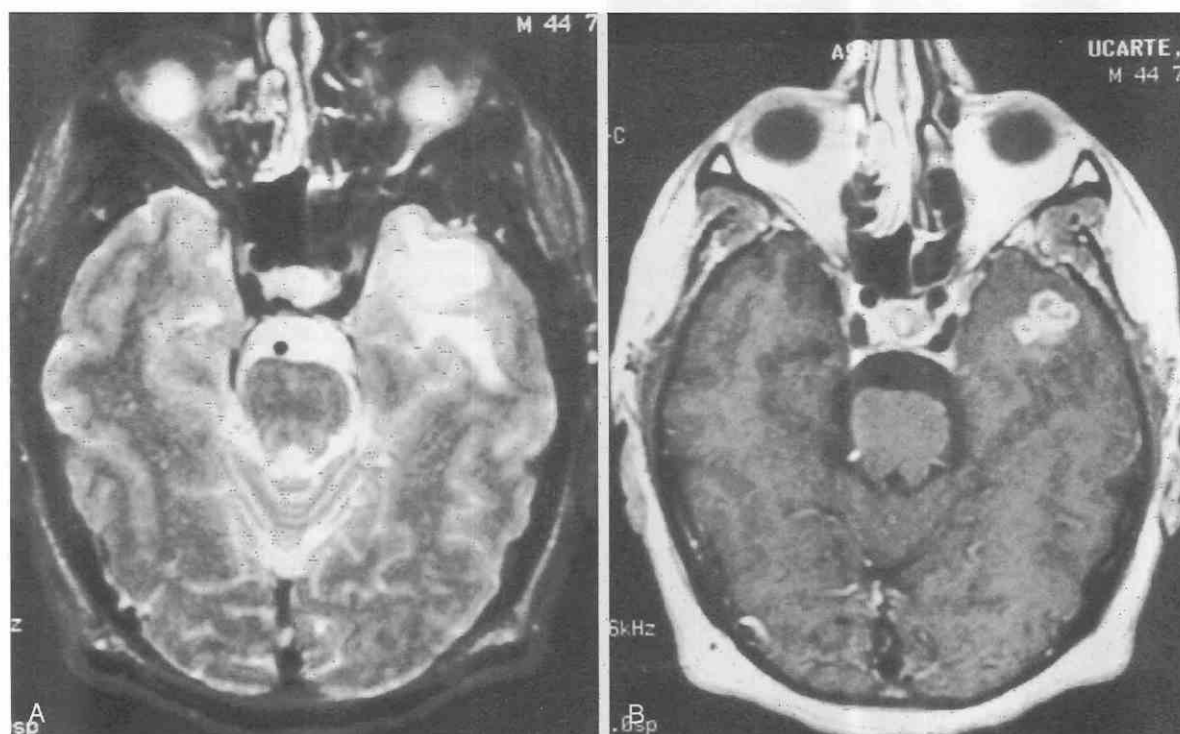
Tuberculoma. *A*, T2-weighted image shows an area of high signal intensity in the left temporal lobe. *B*, Gadolinium-enhanced MRI study demonstrates multiring enhancement with surrounding edema.
